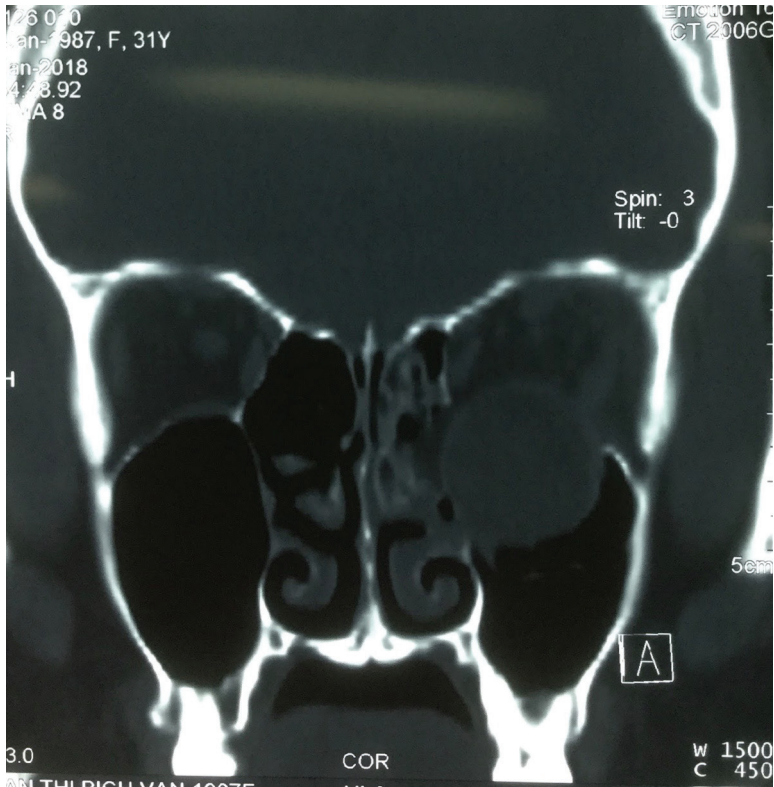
Coronal sections of orbital computed tomography showed: Orbito-ethmoidal complex fractures, orbital floor fractures, with associated sinus effusion. No damage to the meninges, brain and skull. Normal right eye.
